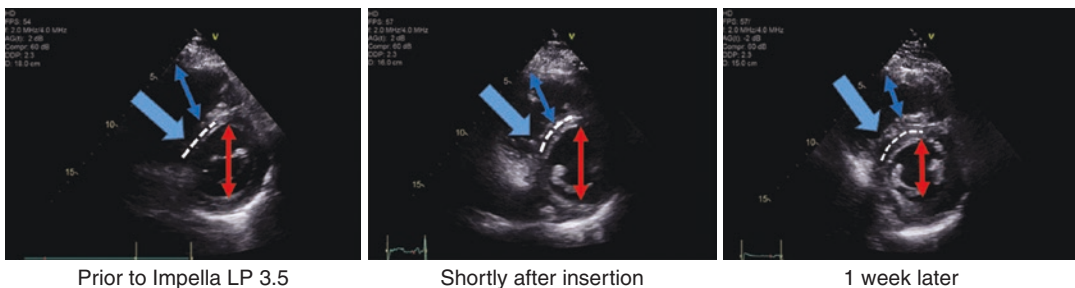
Trans-echocardiograms (short axis) from the case in the text demonstrating LV failure from cardiomyopathy. The first panel is before insertion of the Impella®. The septum is flattened (large blue arrow), the RV is markedly enlarged (double headed blue arrow), and the LV is dilated (double-headed red arrow). The middle
